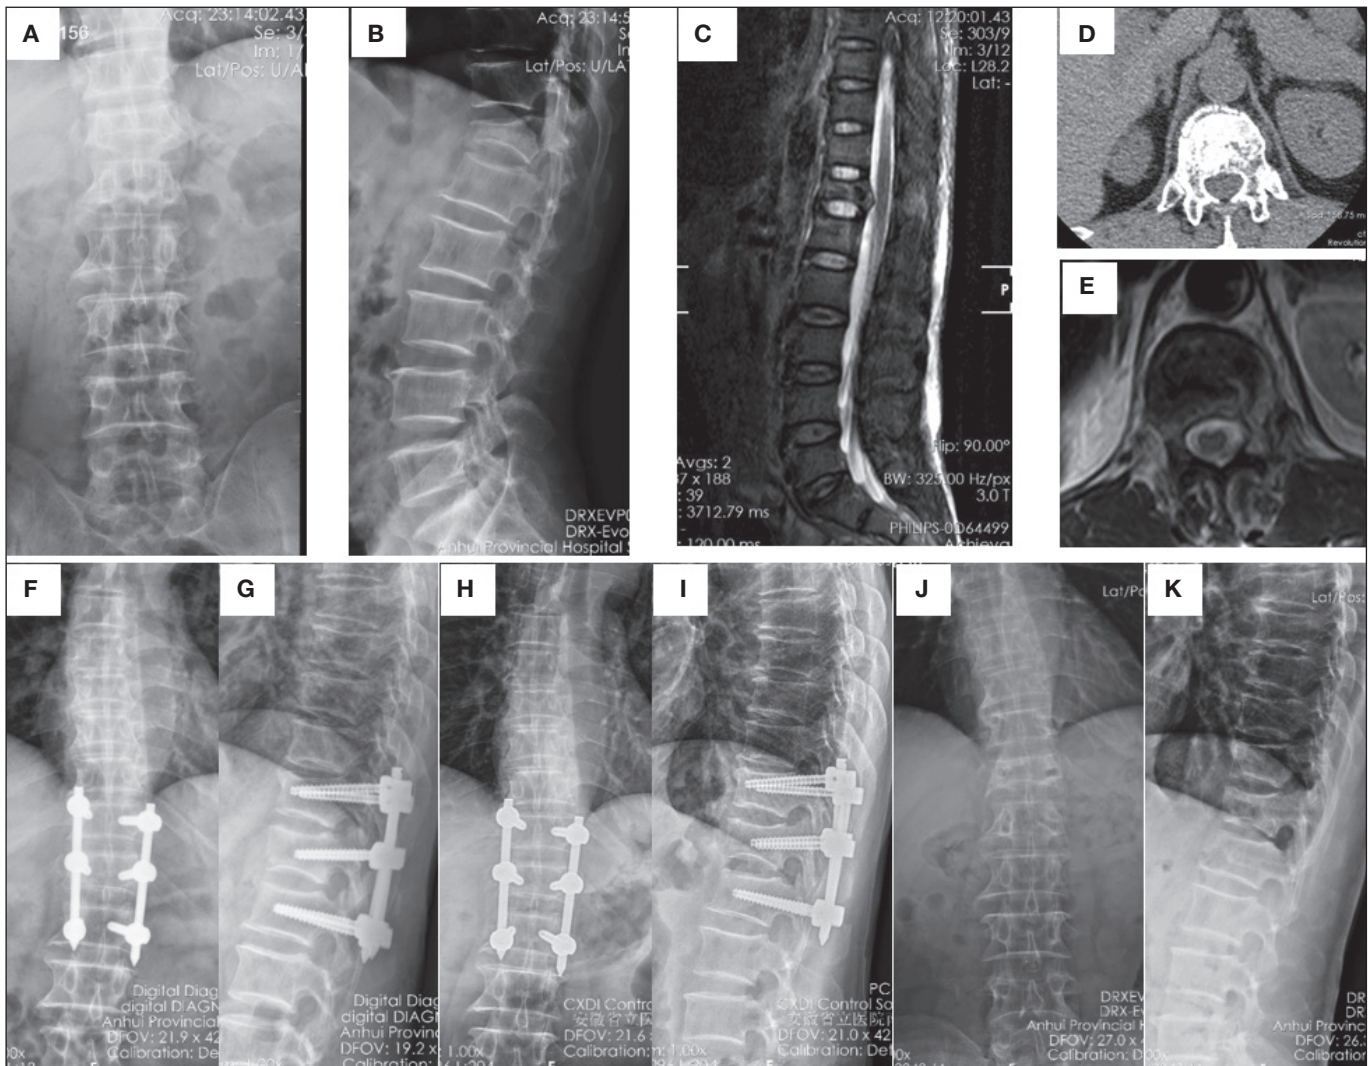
A 50 years old man with T12 burst fracture (B, D), MRI (C) showed posterior ligament complex damaged, preoperative TLICS score was 5, the surgery was done through the novel retractor method. Before surgery (A, B), anterior column height percentage was 46.9%, Sagittal regional Cobb angle was 25.5°; 2 days postoperative (F, G), anterior column height percentage was 93.0%, Sagittal regional Cobb angle was 10.6°; three months postoperative (H, I), anterior column height percentage was 92.1%, Sagittal regional Cobb angle was 11.3°. 13 months postoperative, the screws were taken out, three months after the screws taken out (J, K), anterior column height percentage was 89.2%, Sagittal regional Cobb angle was 9.6°.
